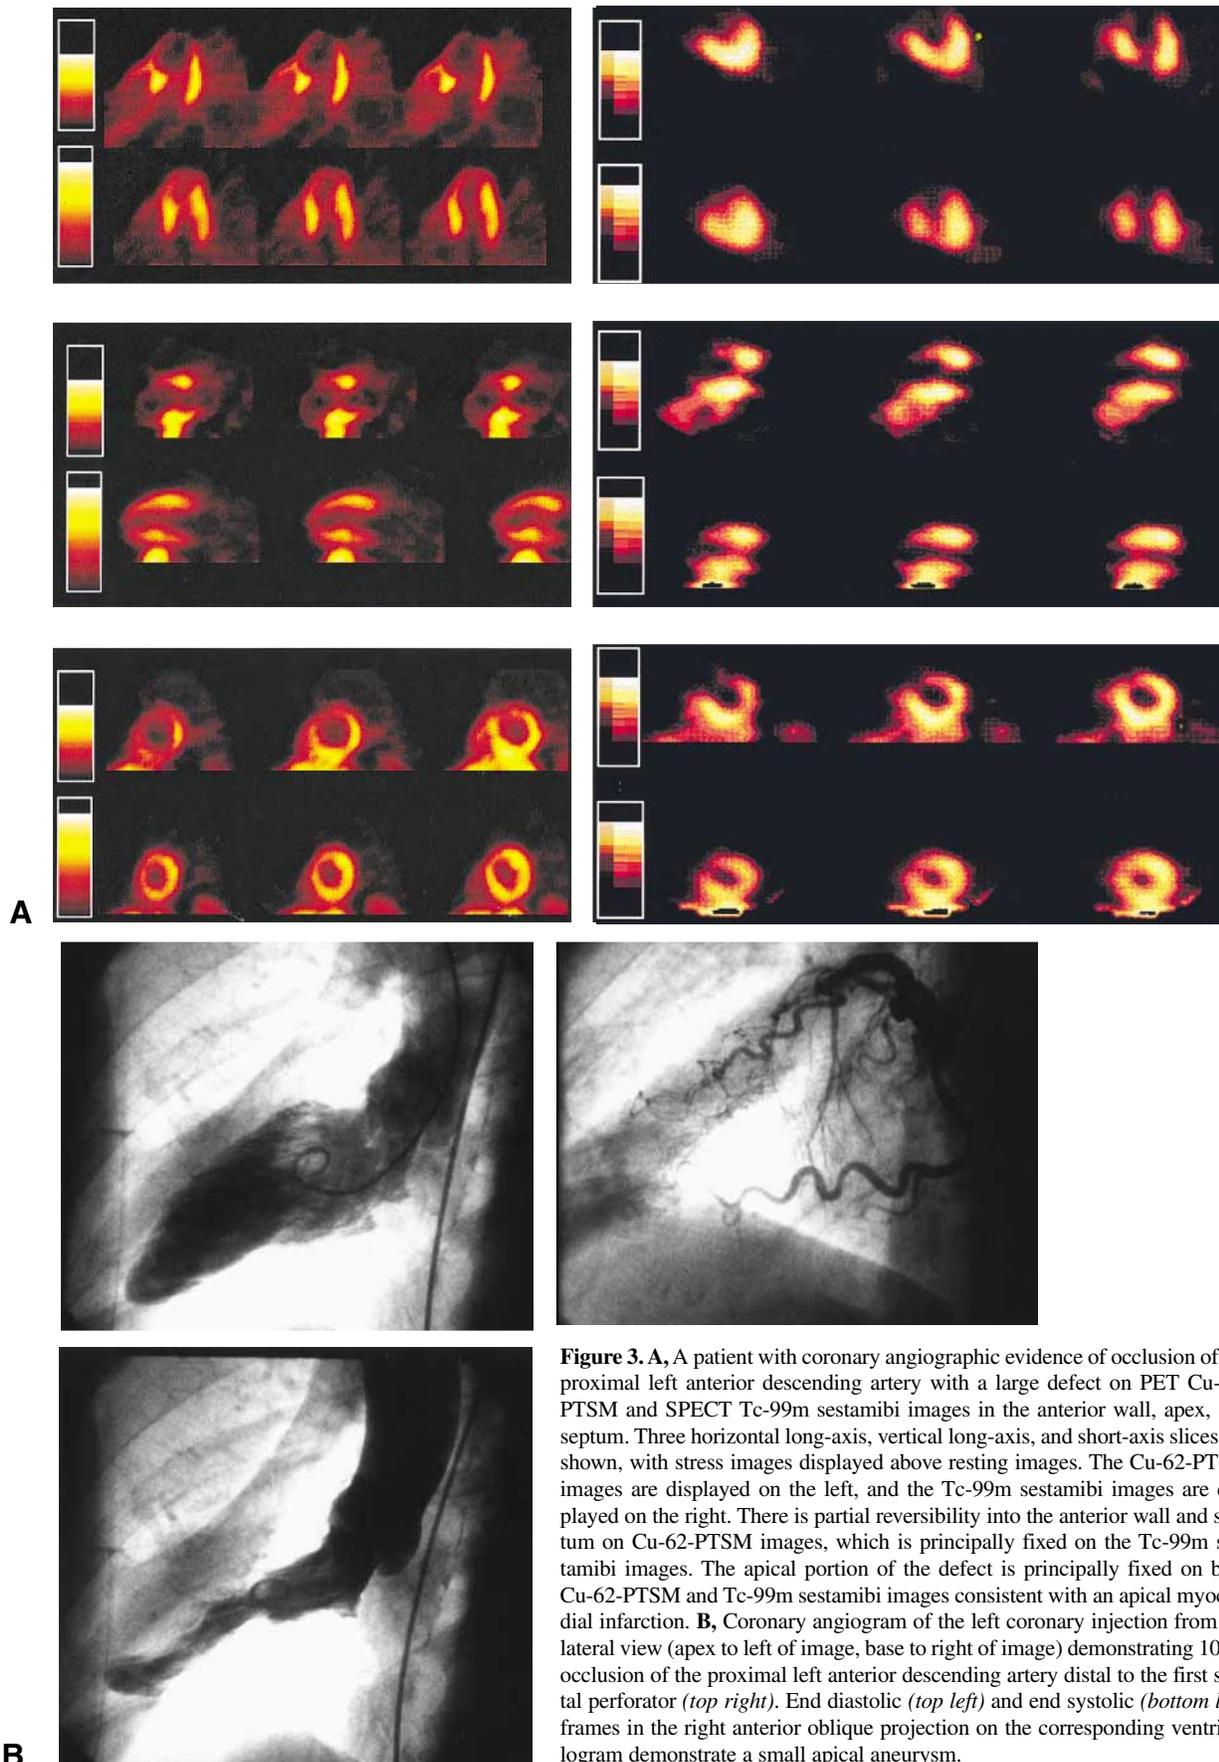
A, A patient with coronary angiographic evidence of occlusion of the proximal left anterior descending artery with a large defect on PET Cu-62-PTSM and SPECT Tc-99m sestamibi images in the anterior wall, apex, and septum. Three horizontal long-axis, vertical long-axis, and short-axis slices are shown, with stress images displayed above resting images. The Cu-62-PTSM images are displayed on the left, and the Tc-99m sestamibi images are displayed on the right. There is partial reversibility into the anterior wall and septum on Cu-62-PTSM images, which is principally fixed on the Tc-99m sestamibi images. The apical portion of the defect is principally fixed on both Cu-62-PTSM and Tc-99m sestamibi images consistent with an apical myocardial infarction. B, Coronary angiogram of the left coronary injection from the lateral view (apex to left of image, base to right of image) demonstrating 100% occlusion of the proximal left anterior descending artery distal to the first septal perforator (*top right*). End diastolic (*top left*) and end systolic (*bottom left*) frames in the right anterior oblique projection on the corresponding ventriculogram demonstrate a small apical aneurysm.
